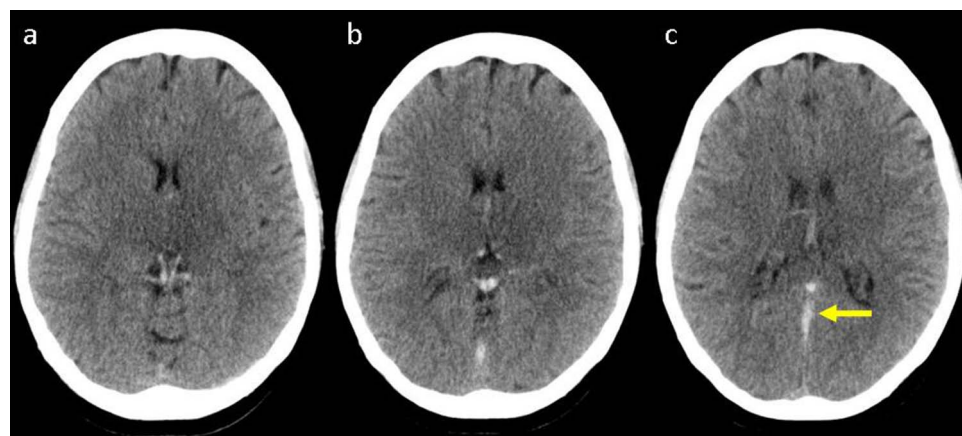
Axial unenhanced CT scans acquired at presentation showing acute thrombus with internal cerebral veins and veins of Rosenthal (A), vein of Galen and straight sinus (B) and straight sinus with cord sign (C, arrowed).
